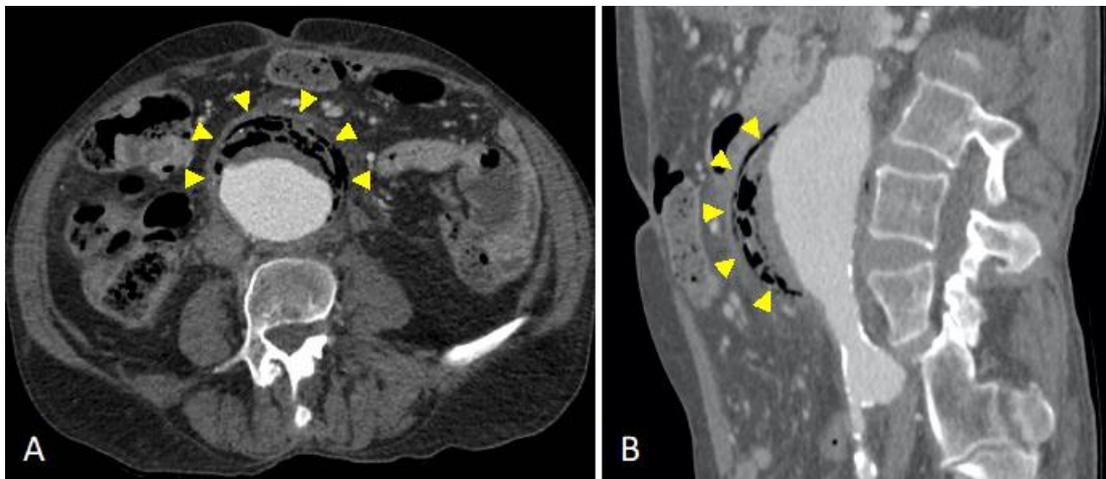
Admission CT scan: A) transverse and B) sagittal view revealed an increase of the aneurysm to 6.1×6.6 cm with gas in the aorta (head arrows).
